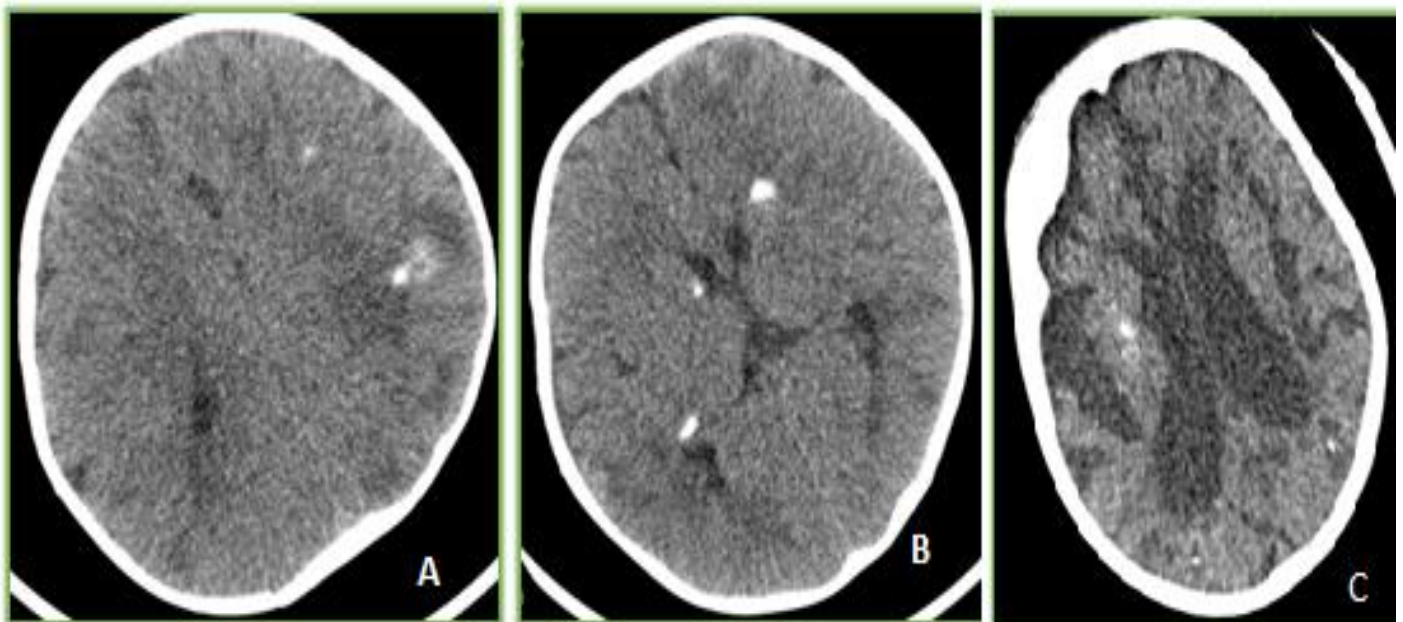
Torch; Nonenhanced CT scan in :a,b) 1-year old child , shows calcifications in bilateral periventricular and left parietal region. c) 2-year old child , shows atrophy of the brain parenchyma with chunky calcifications in right insular cortex and left parietal region.
